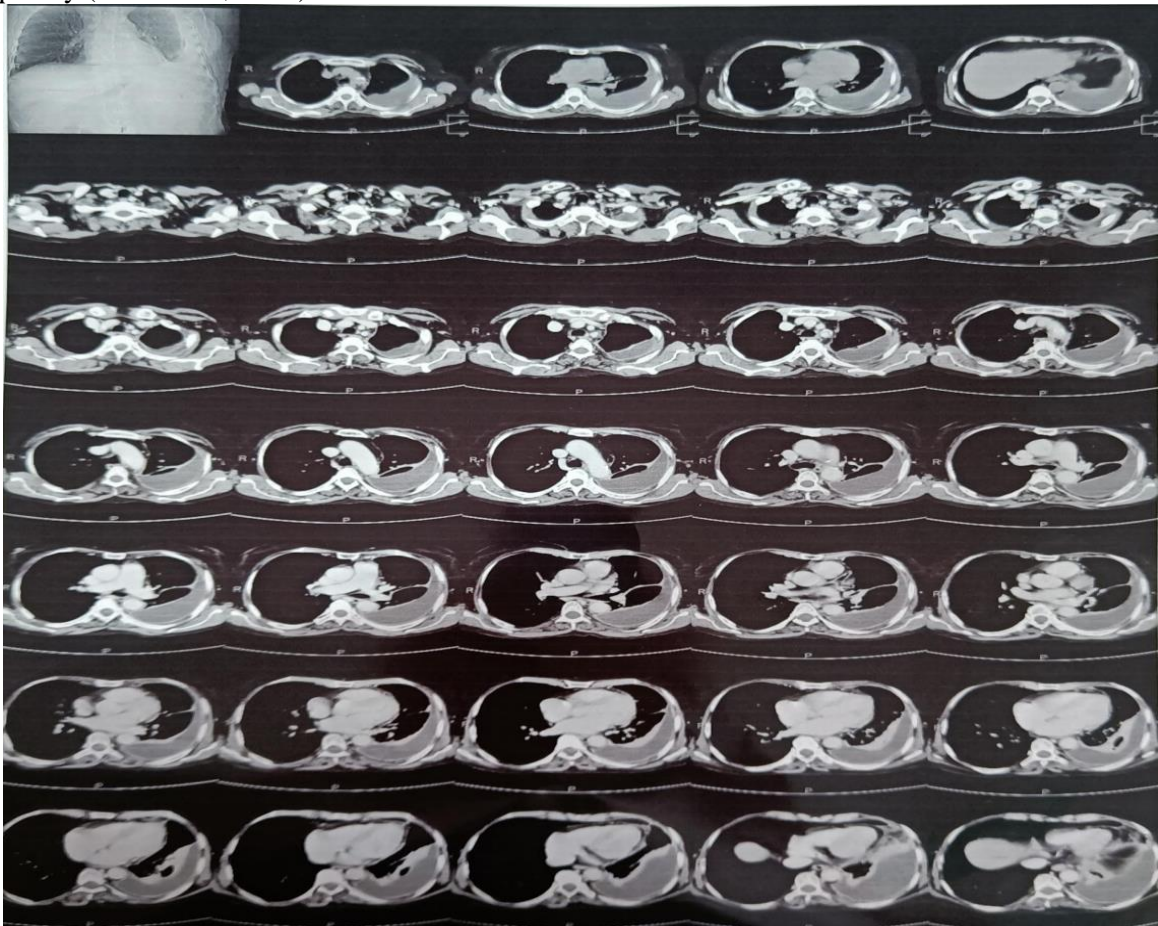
HRCT Thorax (Plain + Contrast) Plural effusion
